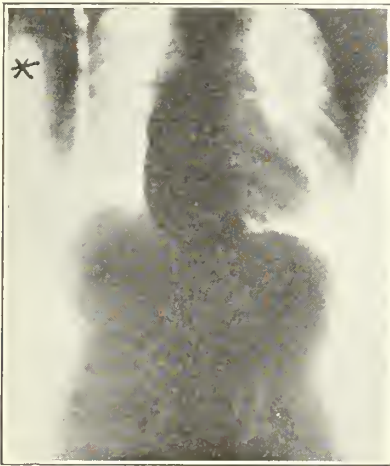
Radiograph of a woman of 45, showing an abdominal esophagismus which was afterward cured by endoscopic mechanical divulsion. The "flat floor" of the dilatation shows why previously used blind methods had failed to introduce any instrument through the hiatus.
